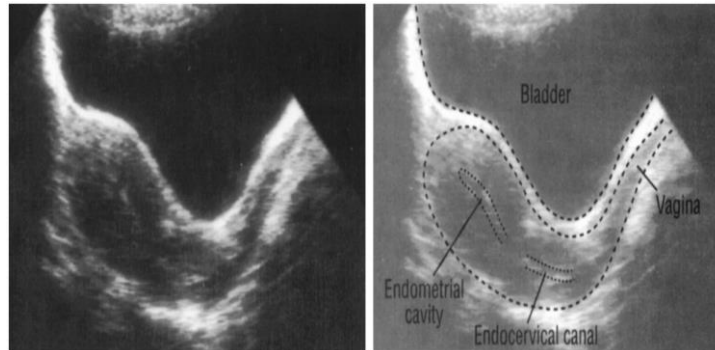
Sagittal TA ultrasound showing anteflexed uterus (Palmer P.E.S et-al 2003)
